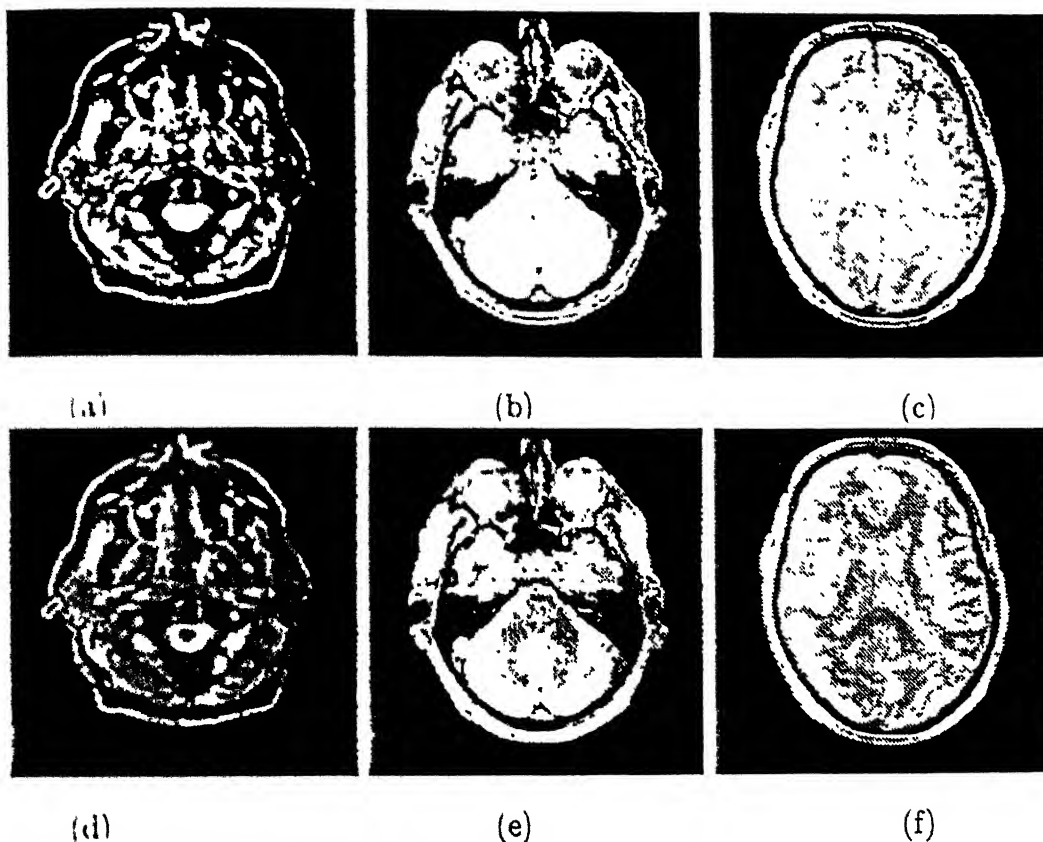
Selected Slices from MRI Data Set 1. (Top) PD-weighted. (Bottom) T2-weighted. (a),(d) Slice 1. (b),(e) Slice 8. (c),(f) Slice 15.
